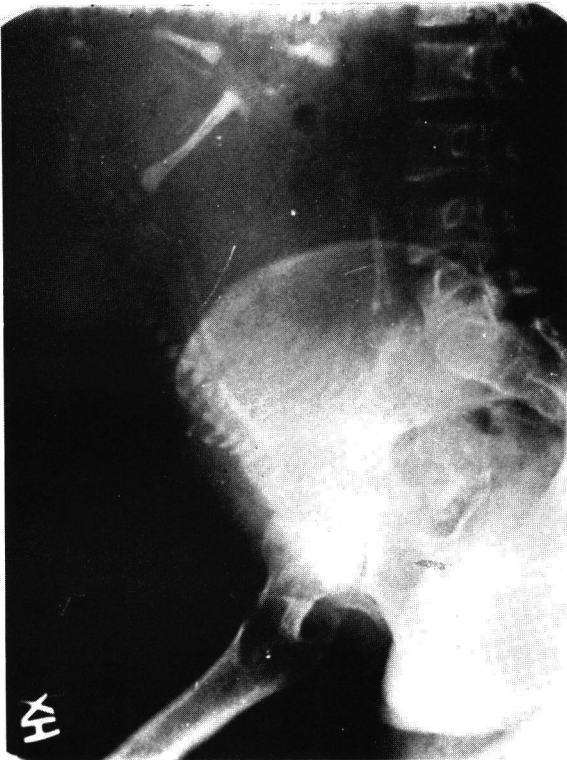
Case 2. X-ray of the abdomen at 36 weeks' gestation. The posture of the limbs of the foetus indicates a grossly enlarged abdomen, leading to a diagnosis of hydrops foetalis. Anencephaly was also present.
